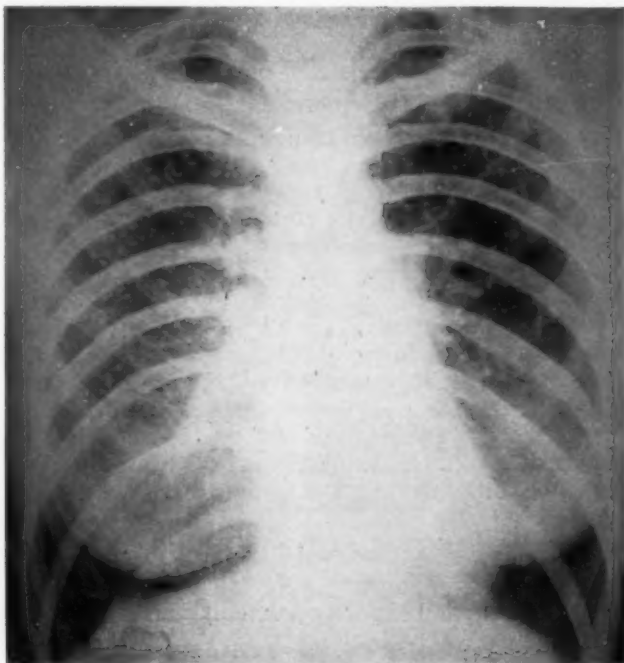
Case 1. Chest roentgenogram showing the typical bilateral nodular infiltrate of eosinophilic granuloma with areas of emphysema and fibrosis.
